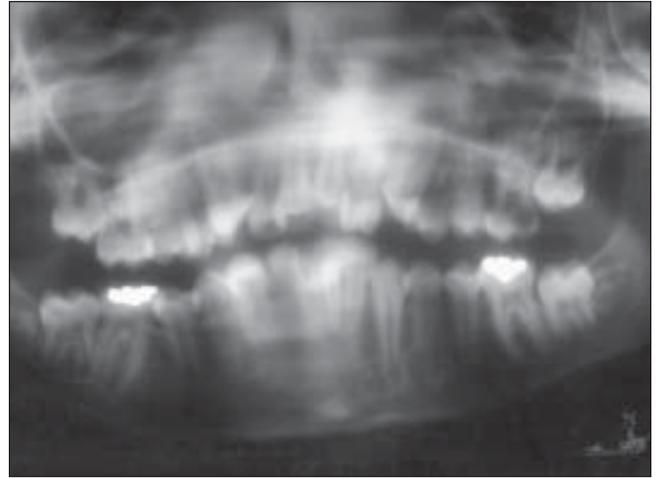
Orthopantomogram shows abnormal root morphology of 22
